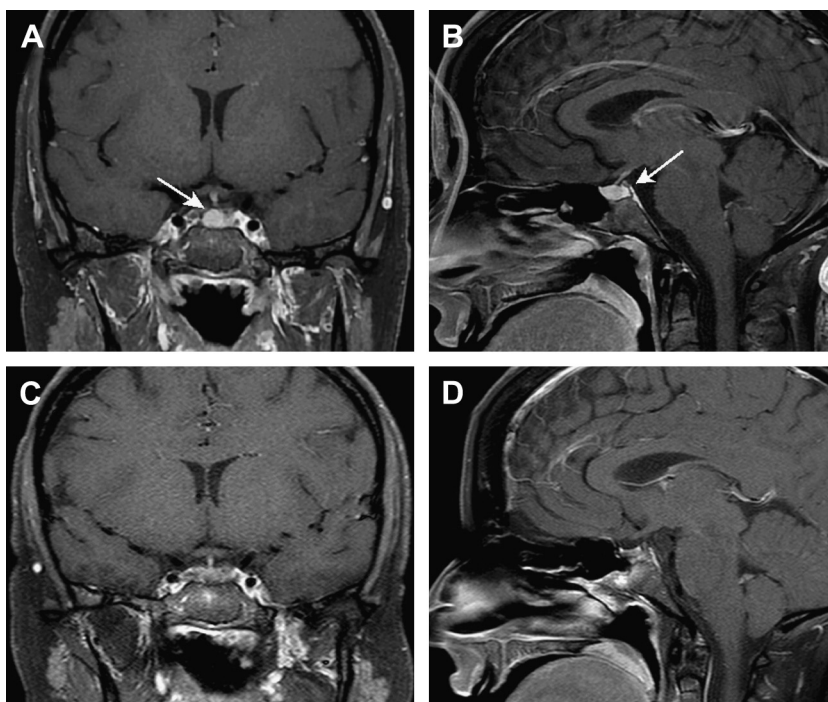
A 29 year-old woman presenting with galactorrhea, found to have a microadenoma on MRI. Despite medical treatment, the tumor size increased. (A, B) Gadolinium-enhanced T1-weighted images show a 7-mm enhancing lesion (arrows). She underwent transsphenoidal resection with complete removal of the lesion (C, D), with normalization of prolactin levels by way of dopamine agonists.
